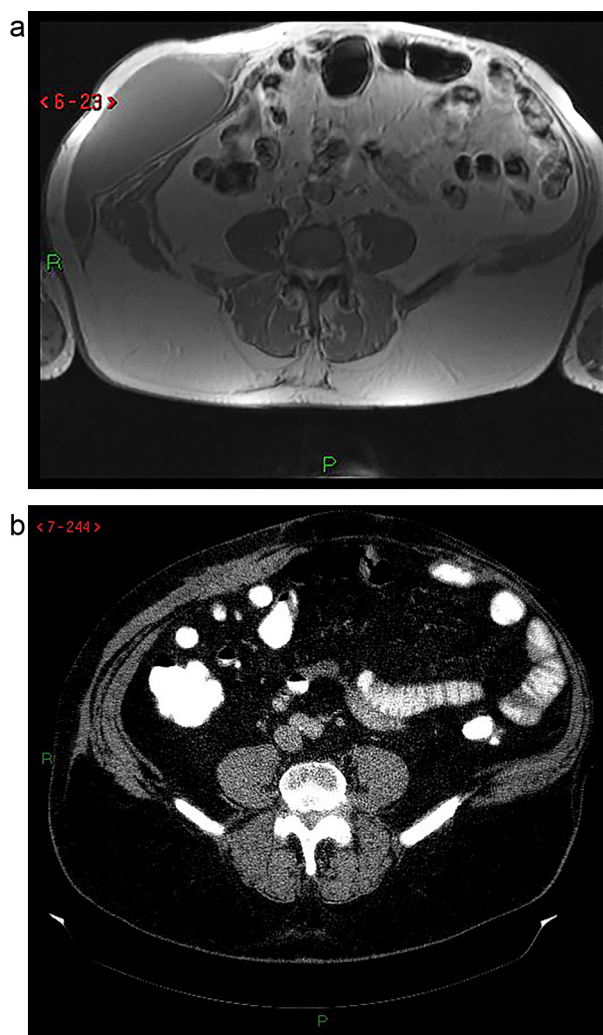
Right abdominal wall chronic hematoma/seroma. a) MRI before treatment. b) CT 4.5 month after treatment with 10 g of 4DryField® PH powder.
